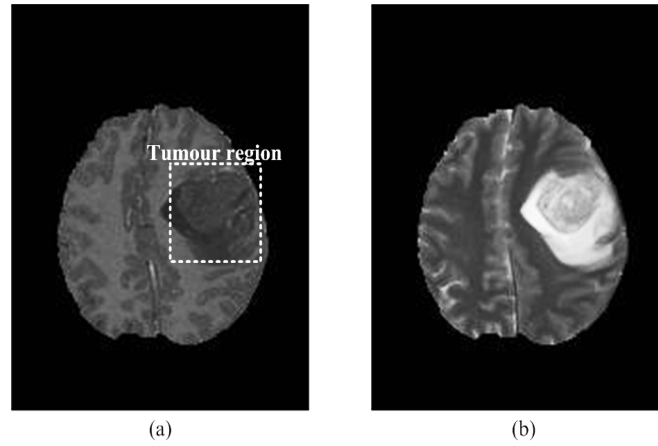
Comparison between (a) T1-weighted and (b) T2-weighted brain MR images (*BRATS: Multimodal Brain Tumor Segmentation Challenge*, 2015).
